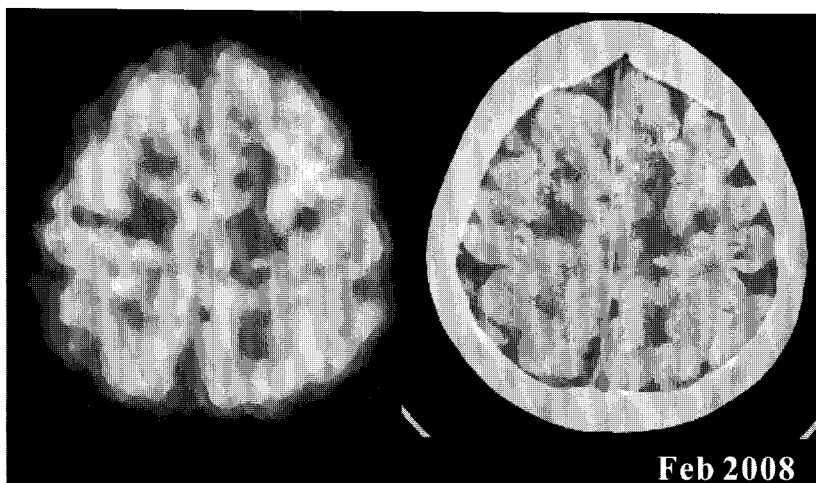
This is a baseline F-18 FDG PET/CT done for staging in a 60-year-old woman with NSCLC in left lung. The FDG PET scan was done 1 hour after the intravenous injection of 370 MBq (10 mCi) of F-18 FDG. The FDG PET/CT scan did not demonstrate significant change of FDG uptake throughout cerebral hemisphere.
